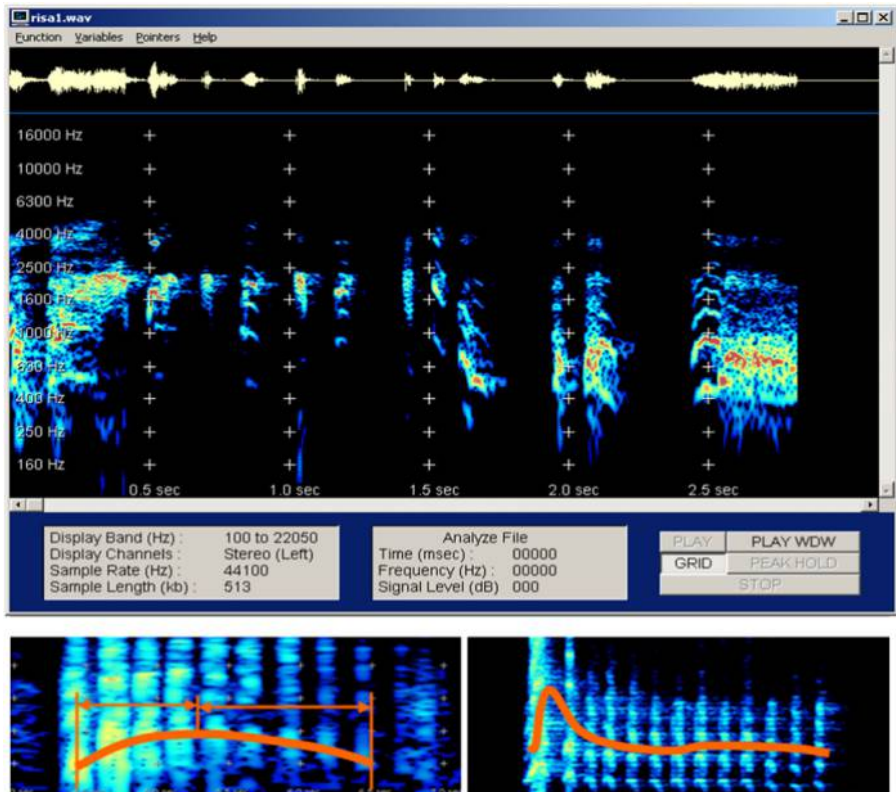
Sonogram of a “well-formed” laughter recorded during the joyful play of a toddler (recorded by PCM)
